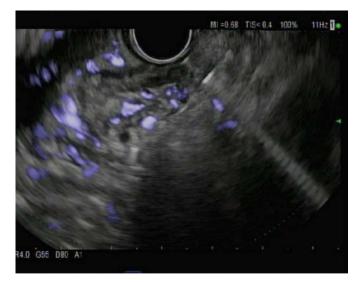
Endoscopic ultrasound–guided coil injection into gastric varices.
